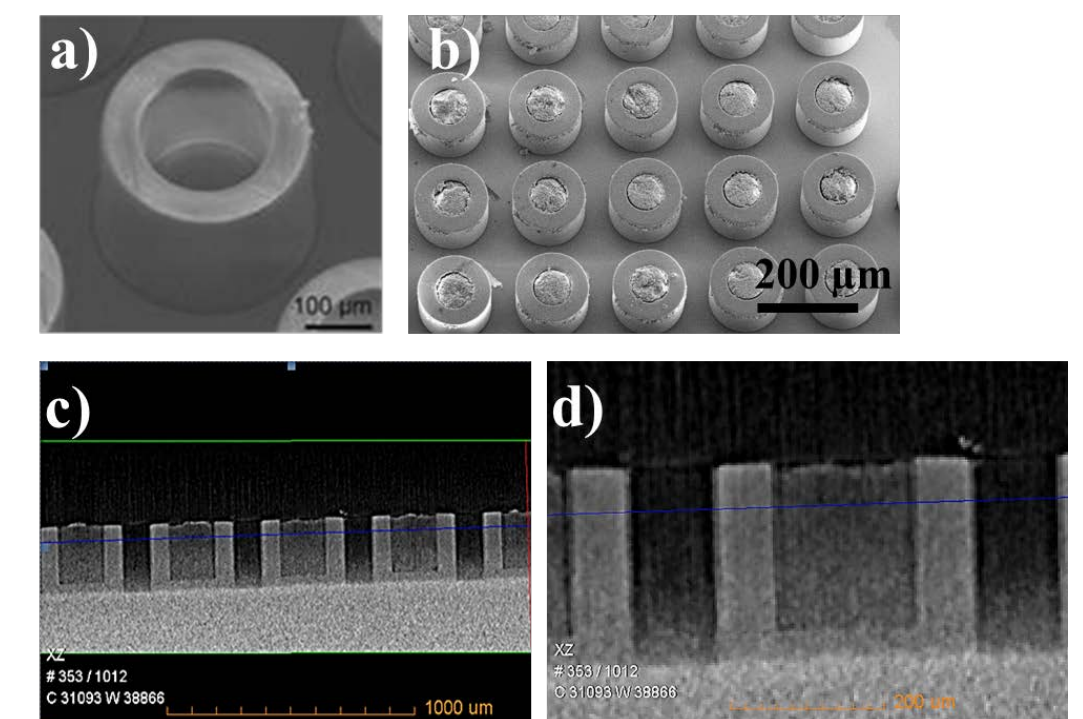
a+b) SEM image of and empty microcontainer (a) and microcontainers loaded with cubosomes (b). c+d) X-ray microtomography images of the loaded microcontainers.
